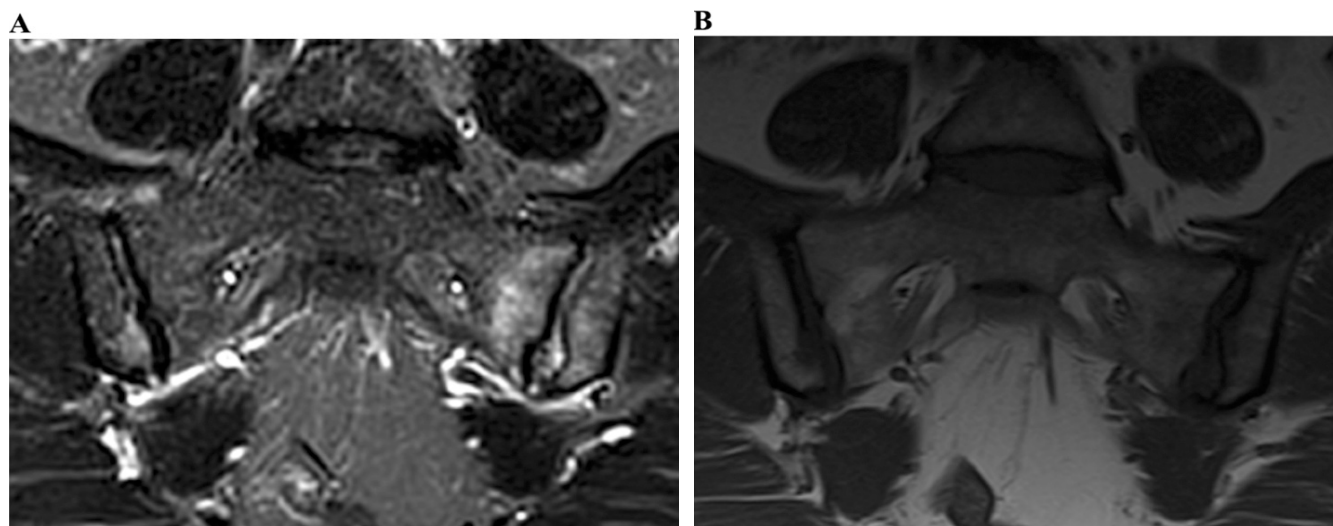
ASAS positive MRI for active sacroiliitis in a 58-year-old woman with non-radiographic axSpA. Semi-coronal STIR image (A) and corresponding semi-coronal TSE T1-weighted image (B) show subchondral bone marrow oedema in both sides of the left SIJ and in the right inferior iliac quadrant. ASAS: Assessment of SpondyloArthritis international Society; MRI: magnetic resonance imaging; axSpA: axial spondyloarthritis; STIR: short tau inversion Recovery; TSE: turbo spin-echo; SIJ: sacroiliac joint.
